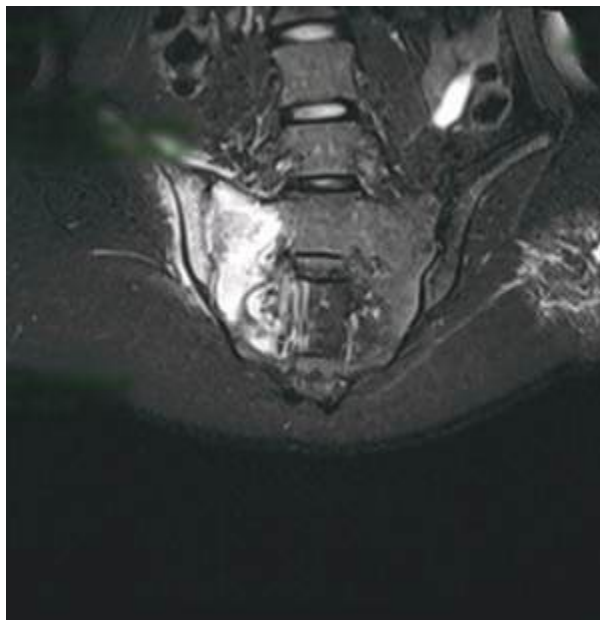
Coronal T2-weighted MRI displaying extensive hyperintense bone marrow edema and inflammatory changes involving the right sacroiliac joint and adjacent sacral ala, consistent with active sacroiliitis.
